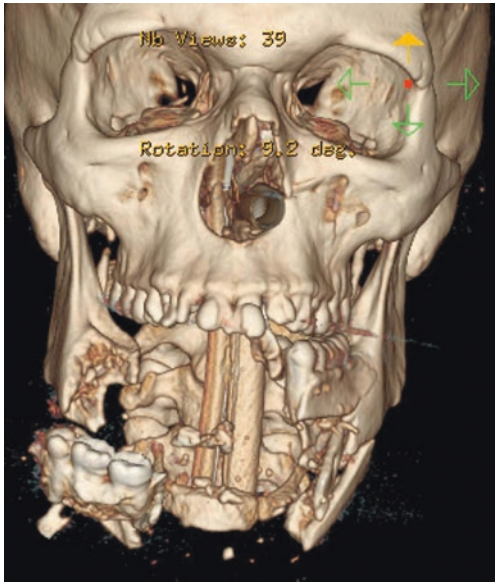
3D CT demonstrating the extensive bone destruction with mandible defect
